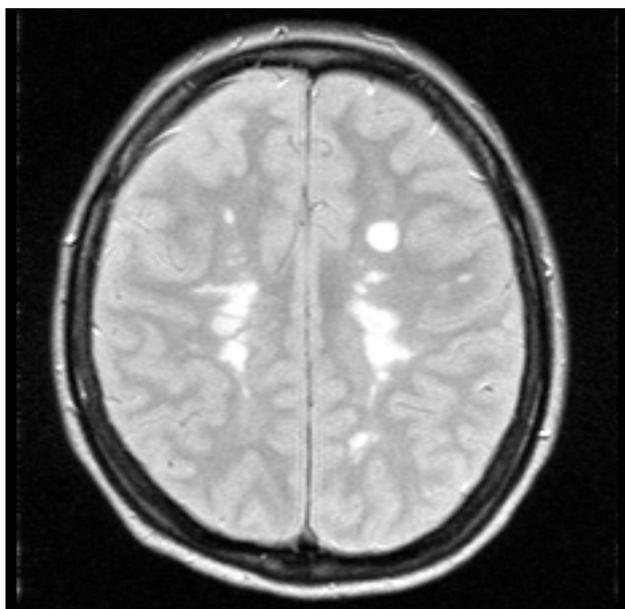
Demyelinating lesions in the axial proton-density MRI scan.
